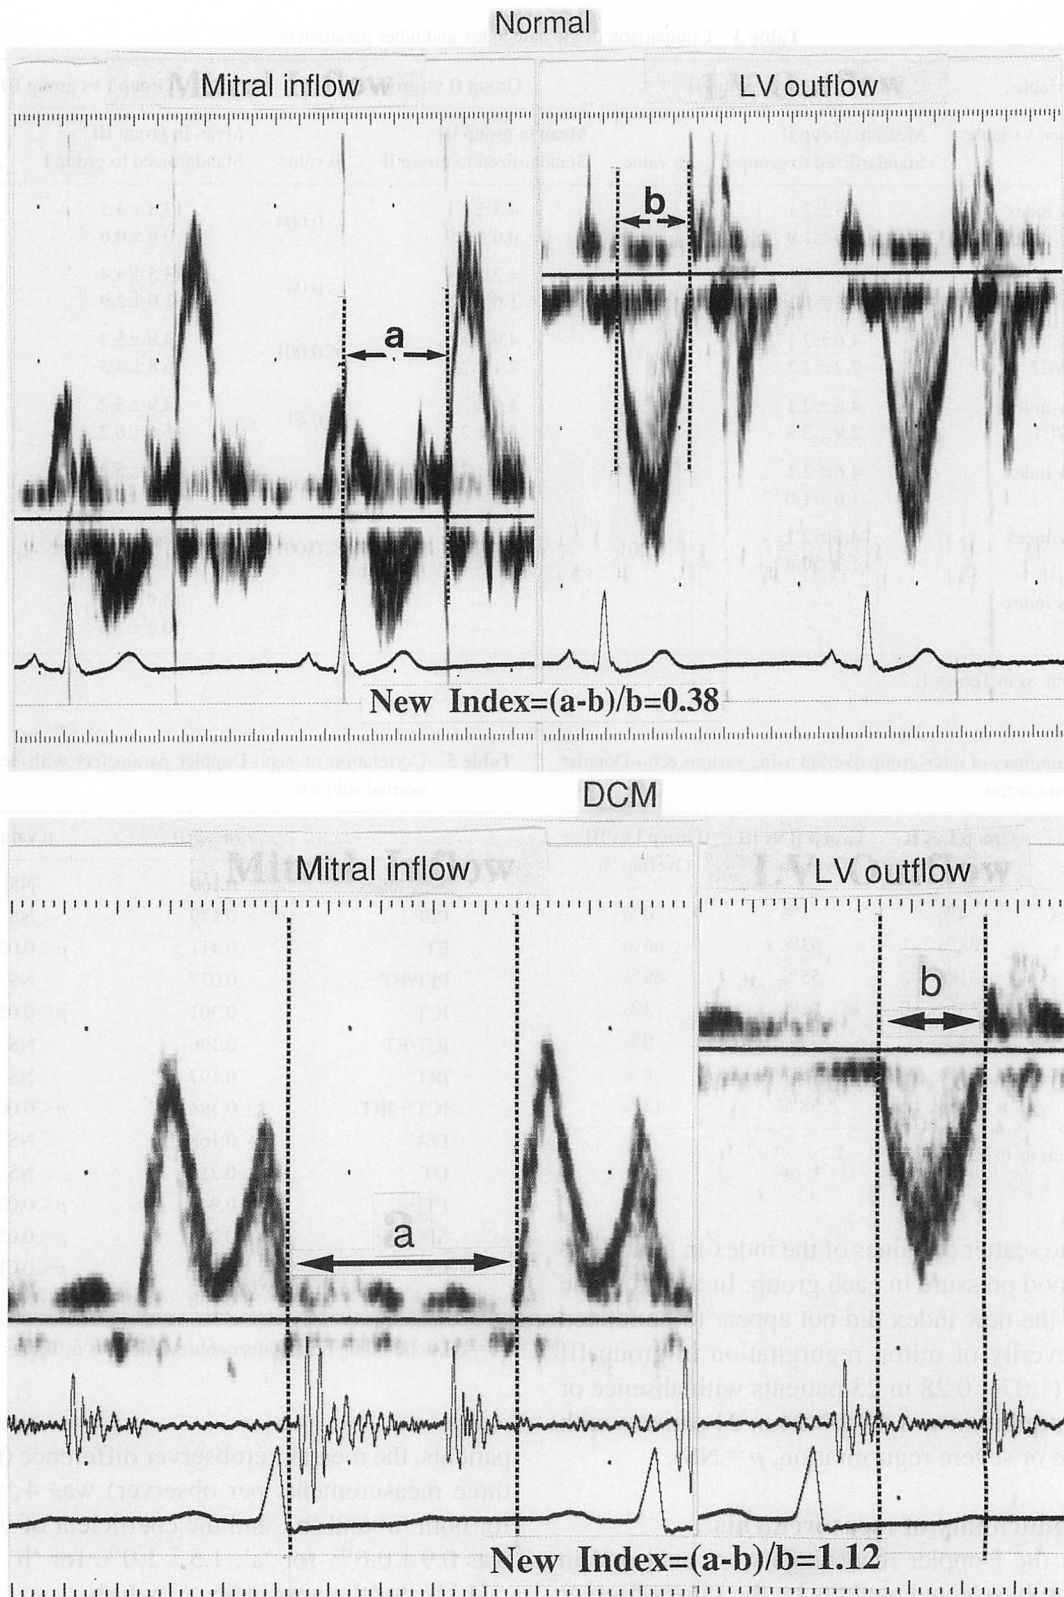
An example of the measurement of Doppler time intervals from the pulsed wave Doppler echocardiograms of mitral and left ventricular outflow velocities in a normal subject (*upper*) and a patient with severe dilated cardiomyopathy (DCM; *lower*)
